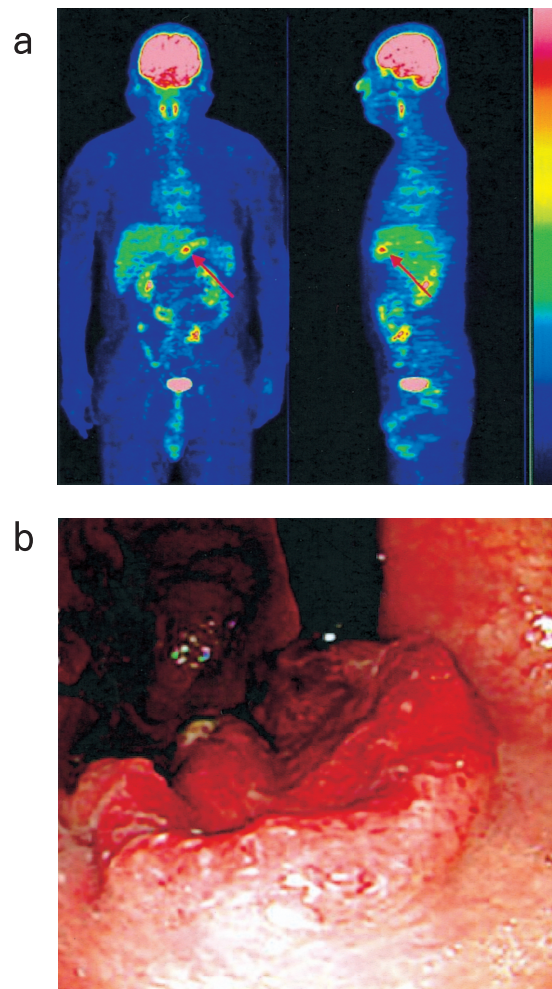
a An accumulation of FDG was observed on the gastric parietal wall. The level of SUV was 6.08 (delay imaging 8.36, Max). In addition, we recognized two thin accumulation images in the circumference near the main lesion and thus diagnosed the patient to have metastatic lymph nodes (each SUV ; 3.32, 3.00)
